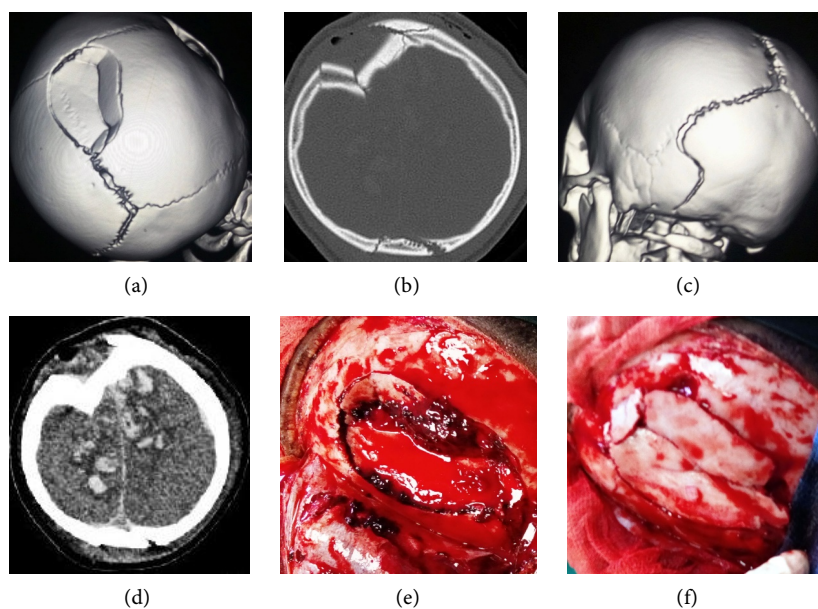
Clinical case of depressed skull fracture. This 11 years-old boy was struck on the head by a falling object. He presented at the emergency department with agitation, consciousness disturbance with left side hemiplegia. The admission Glasgow coma scale (GCS) score was 11. The computed tomography scanning of the head showed a right anterior parietal parasagittal depressed skull fracture crossing the midline ((a), (b)) with dislocation of the posterior half of the sagittal suture and the left part of the lambdoid suture (c); Multiple brain contusion were present under the depressed bone fragments (d); Intraoperative view of the depressed skull fracture before (e) and after elevation of bone fragments (f). The postoperative course was unremarkable. The GCS score returned to 15 three days after surgery and the left hemiplegia was regressing by the time the child was discharged from hospital at day 7 post-surgery.
